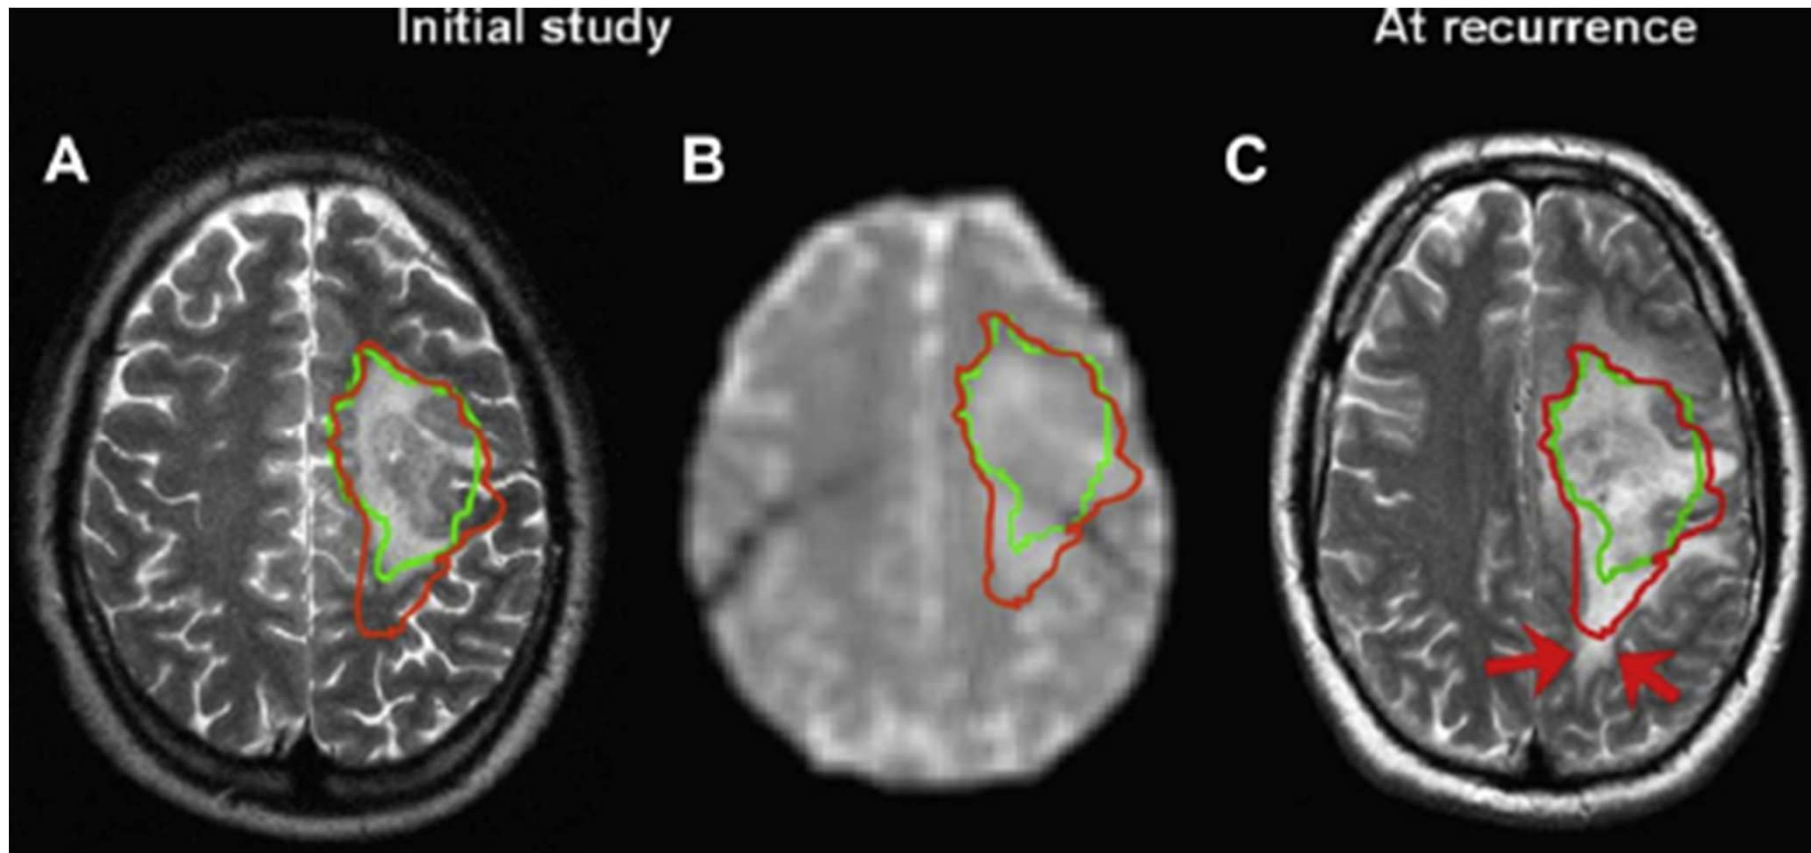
An example of the use of diffusion tensor imaging (DTI) to predict patterns of recurrence. This patient with a glioblastoma developed localised recurrence whose position was predicted by the DTI. The images show a T2-weighted image of the tumour before radiotherapy (A), a map of the isotropic component of the DTI carried out at the same time (B) and a T2-weighted image carried out after tumour progression (C). These images have been co-registered with the isotropic (green) and anisotropic (red) tensor abnormalities. There is a mismatch posteriorly where the anisotropic abnormality is greater than the isotropic abnormality. Imaging showed recurrence with a localised growth pattern in this
